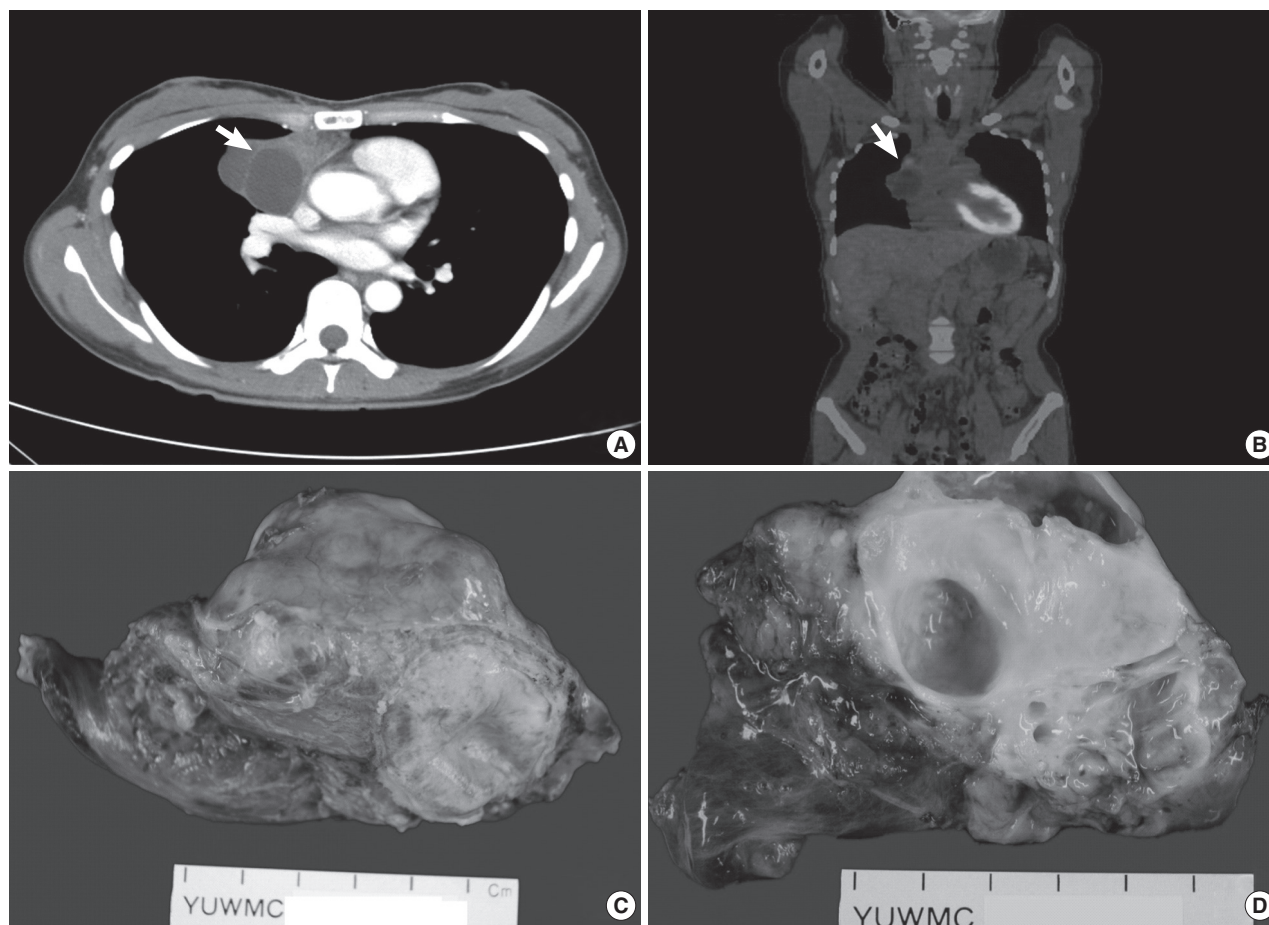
Radiologic and gross findings. (A) The chest computed tomography (CT) shows a 5.6×4.4 cm sized, multiloculated cystic mass (arrow) with heterogenous enhancing septa (37–57 hounsfield unit) in the right anterior mediastinum. (B) On positron emission tomography-CT scans, the solid part of the mass shows nodular F-18 fluorodeoxyglucose (FDG) uptake. There is no remarkable FDG uptake in the entire body. (C) A round mass with a smooth, lobulated external surface. (D) The cut surface reveals yellow-white solid mass with multiple cysts of variable sizes, filled with mucinous fluid.
